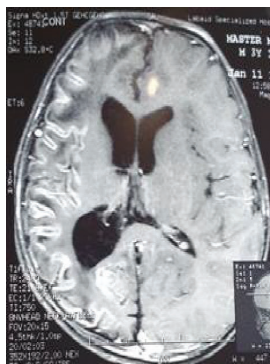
Hyperintense right cerebral hemisphere with leptomeningeal enhancement in FLAIR at 40 th month of age
